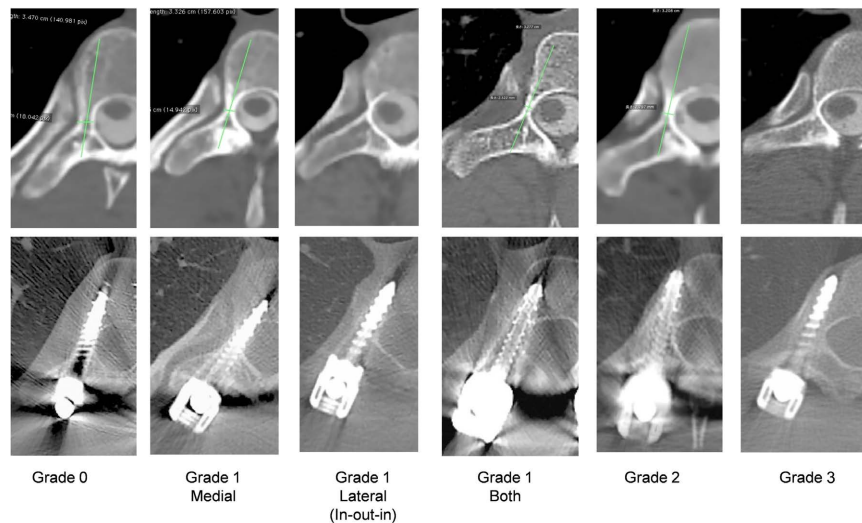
Classification of screw perforations. Inserted screws were categorized to four grades depending on the degree of perforation from the pedicle wall on postoperative CT. CT: Computed Tomography.
